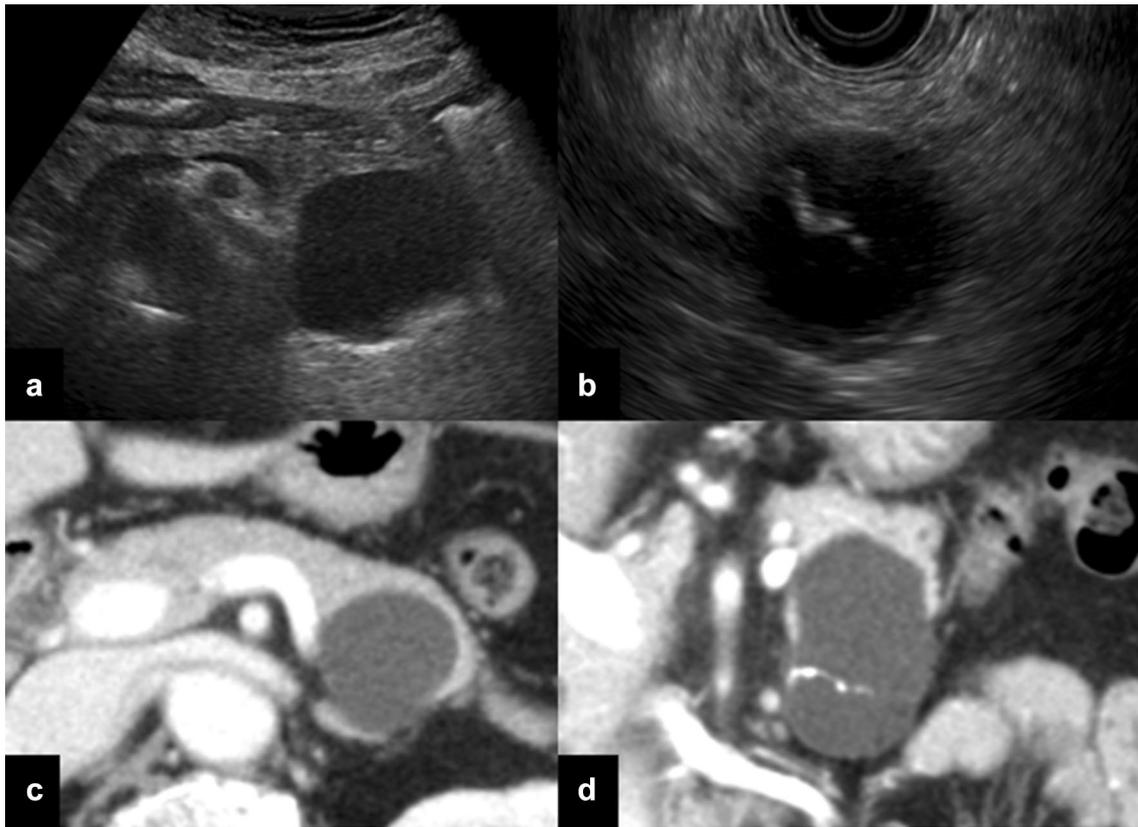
The cystic lesion in the pancreas with multiple modalities. a Transabdominal ultrasound showing a round-shaped 43×38 mm cystic lesion in the tail of the pancreas. b Endoscopic ultrasonography using a forward-viewing radial echoendoscope (EG-580UR, Fujifilm medical, Tokyo, Japan) showing a round cystic lesion with lateral
